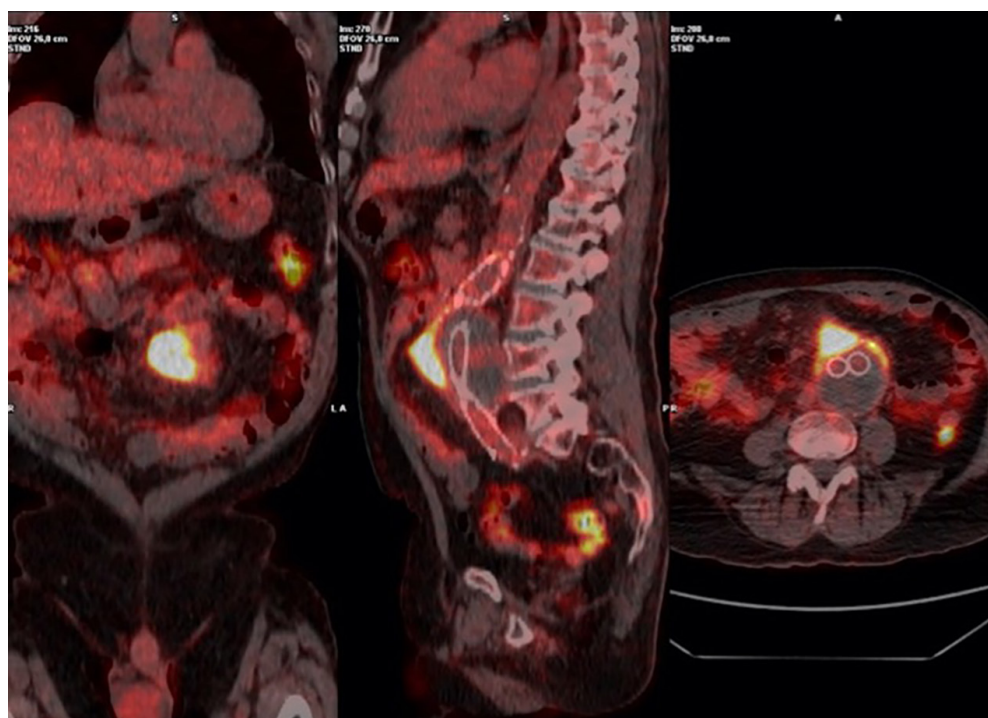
Superimposed $[^{18}\text{F}]$ FDG PET/CT images in the coronal, sagittal and transaxial view (left to right, respectively) better characterizing the extension and the intensity of the radiopharmaceutical uptake at the antero-lateral side of the aortic wall, at the site of the mesenteric enlarged lymph node, and at the anterolateral vascular wall of the native abdominal aorta.
